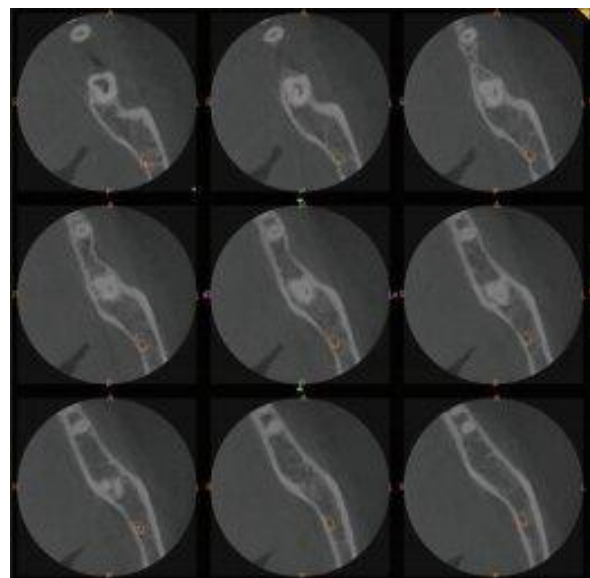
CBCT Axial view .
